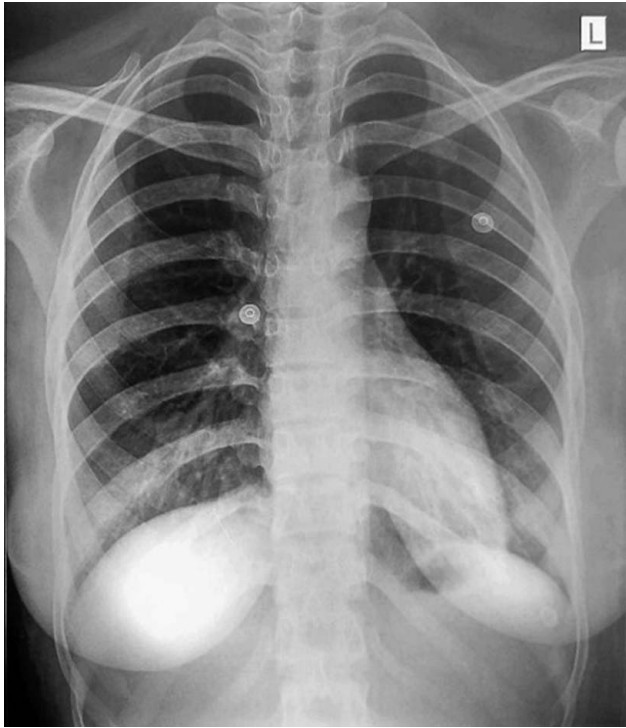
Normal chest radiography findings.
